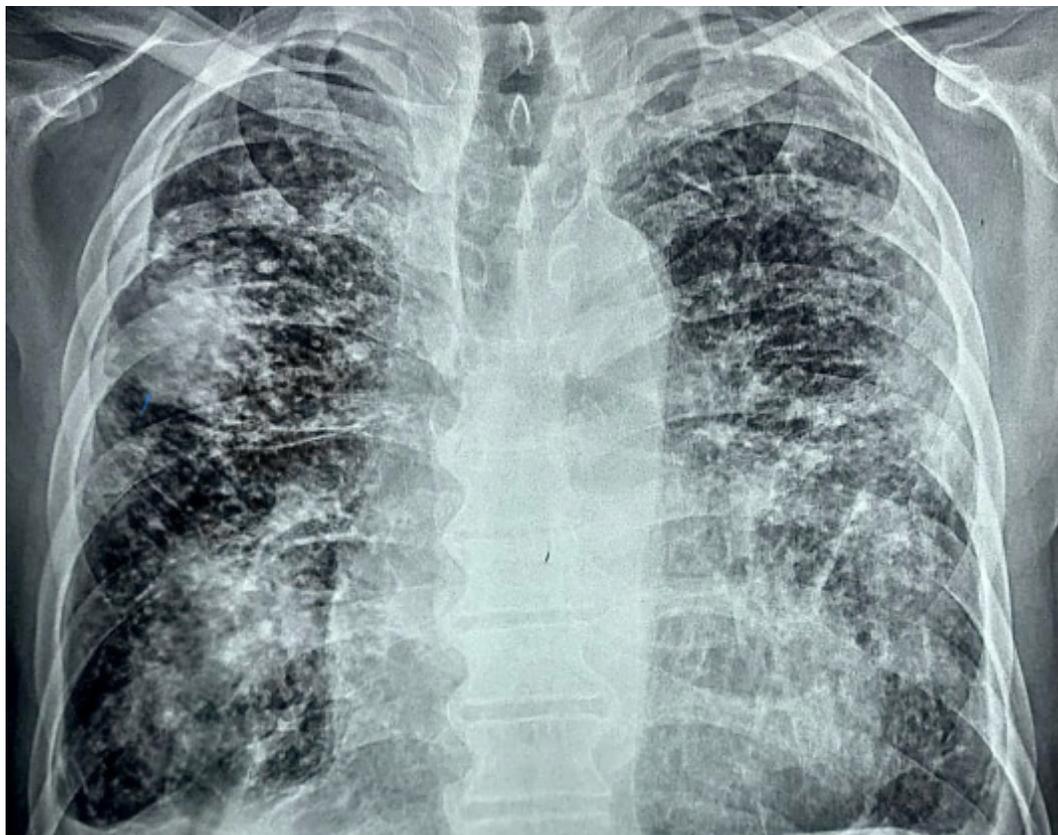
Postero anterior chest radiograph. It shows microcalcifications with a reticulo-micronodular pattern of diffuse distribution, with alveolar consolidation in the right upper lobe and in the lower lobe of the same side, with pleural thickening at bibasal level, probable finding due to bilateral pulmonary fibrosis with reduction of the pulmonary parenchyma, magnification of the cardiac silhouette with ventricular predominance, without growth of the pulmonary artery cone or right interlobar artery.
